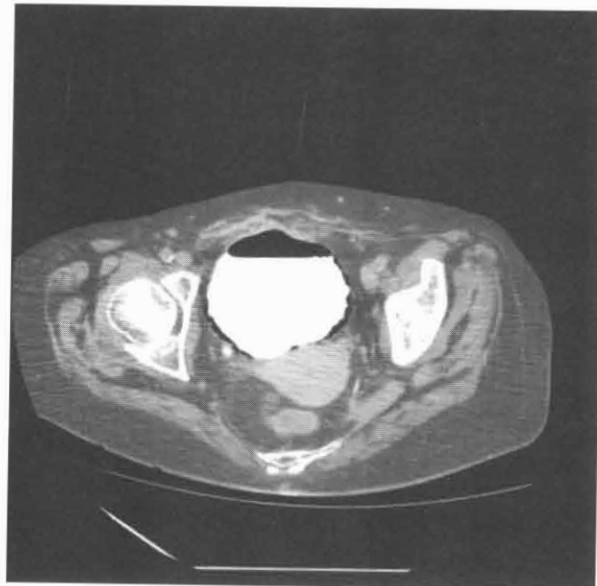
CT scan of abdomen showing gas in urinary bladder wall (arrows)
